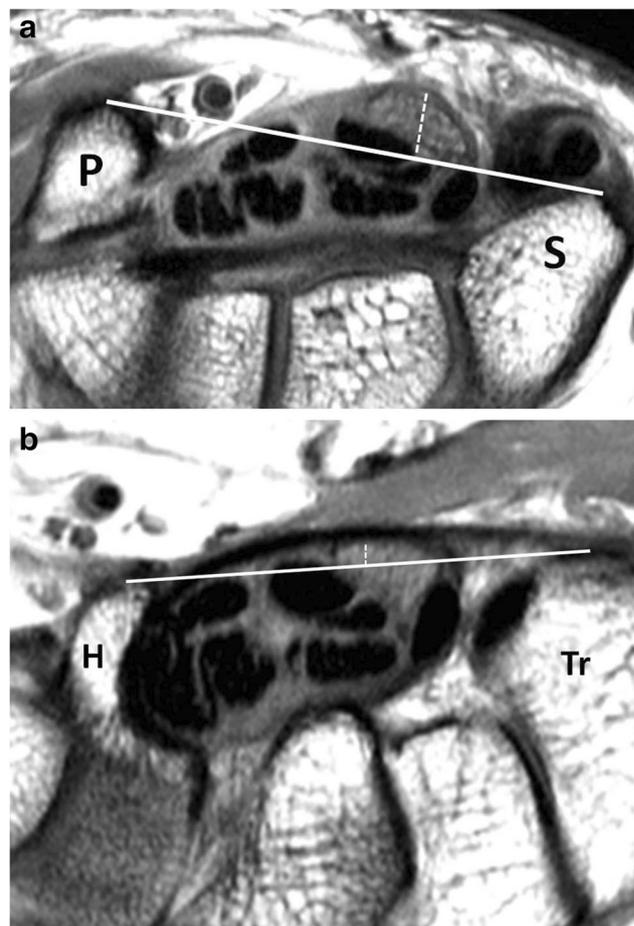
a Proton density axial MR image of a 52-year-old man with CTS showing significant palmar bowing of the retinaculum (*broken line*) above the tangential line (*solid white line*) connecting the scaphoid tubercle (S) and the pisiform bone (P). b Proton density axial MR image of the same CTS patient at the tunnel outlet showing significant palmar bowing of the retinaculum (*broken line*) above the tangential line (*solid white line*) connecting the trapezium tubercle (Tr) and the hook of hamate (H)
